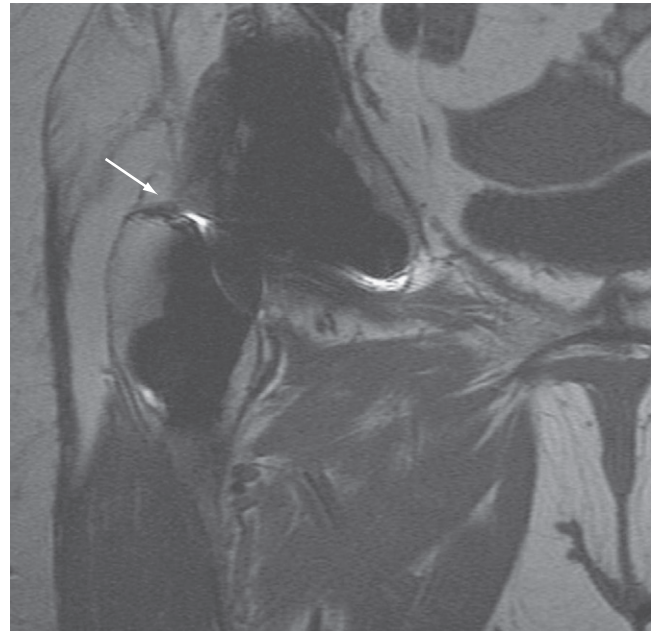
This short tau inversion recovery coronal magnetic resonance image shows a complete avulsion of the gluteus medius tendon from its insertion on the greater trochanter. Note the signal change along the lateral aspect of the greater trochanter, consistent with accumulation of intra-articular gadolinium at the site where the gluteus medius tendon should be.
